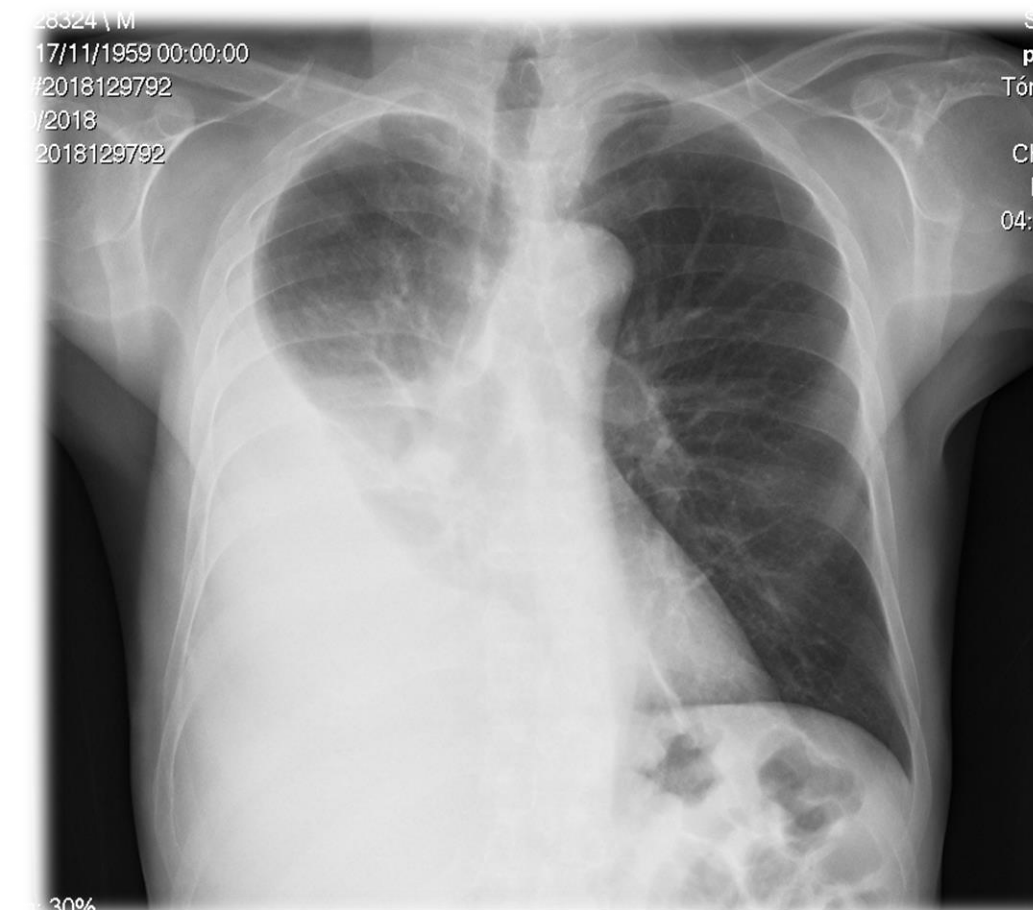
Chest radiography in the Emergency Department after Thoracocentesis
